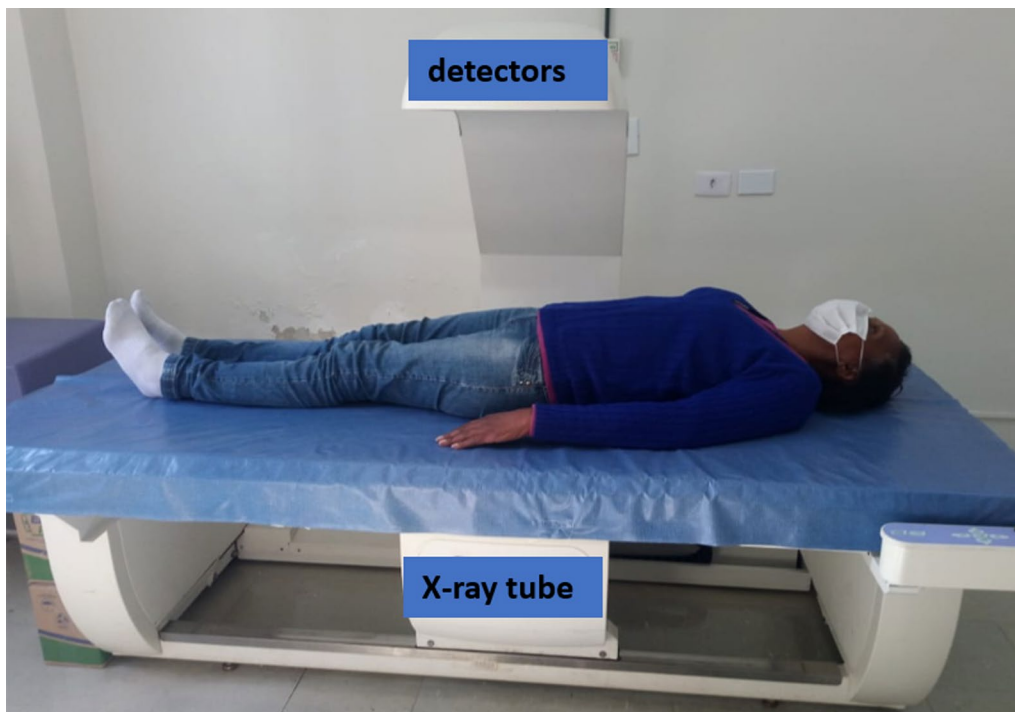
Fundamental principles of dual-energy X-ray absorptiometry (DXA): the X-ray source located at the base of the equipment emits high and low energy X-ray beams that are captured by the detectors for assessment of interaction and differences between the three compartments evaluated by DXA
